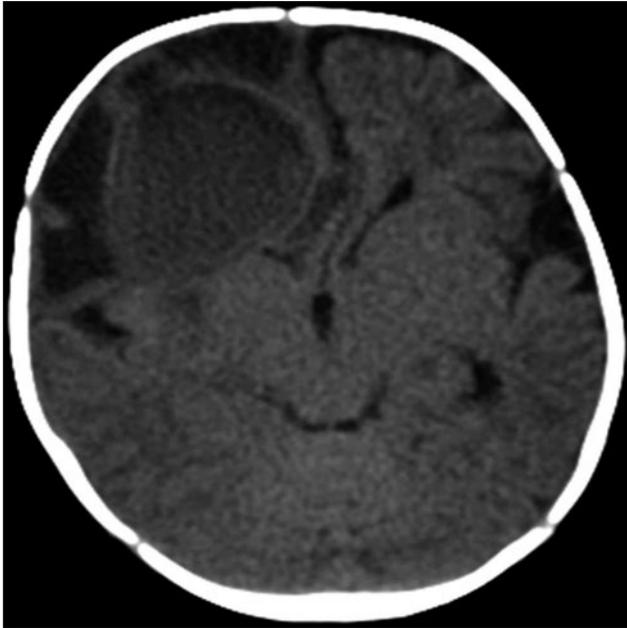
Axial computed tomographic scan of the head (without contrast) showing a right frontal brain abscess with surrounding hypodensity anteriorly and laterally, consistent with vasogenic edema.
